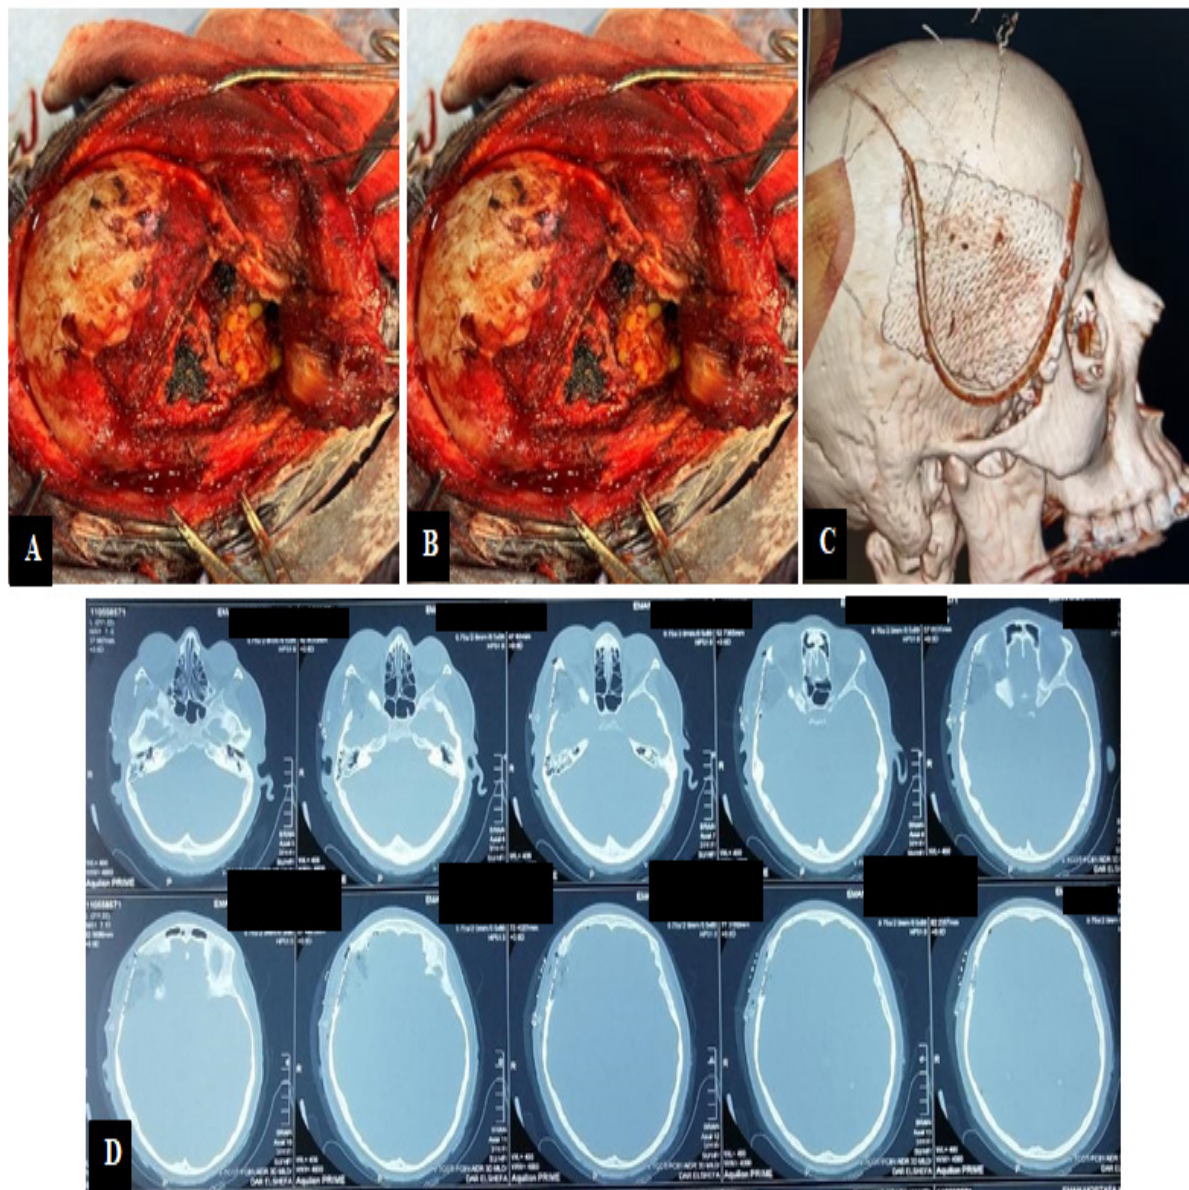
A: Intraoperative image for fascia lata placement showing the fat outside sealing the dura and augmenting the orbit. B: The titanium mesh was placed over the fascia lata and fat graft. C: Post-operative CT scan skull 3D reconstruction showing preservation of orbital walls and mesh used for lateral wall reconstruction below the temporalis muscle. D: Postoperative CT scan of bone window axial cuts showing complete excision of right SOM with orbital reconstruction and evident improvement of right orbital proptosis.
